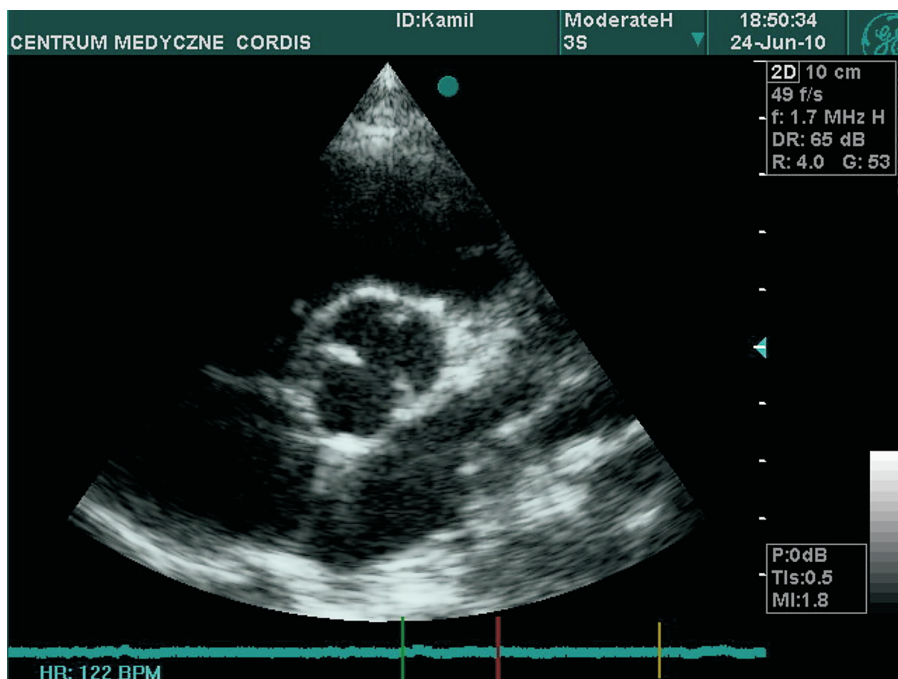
Echocardiography. Bicuspid aortic valve
